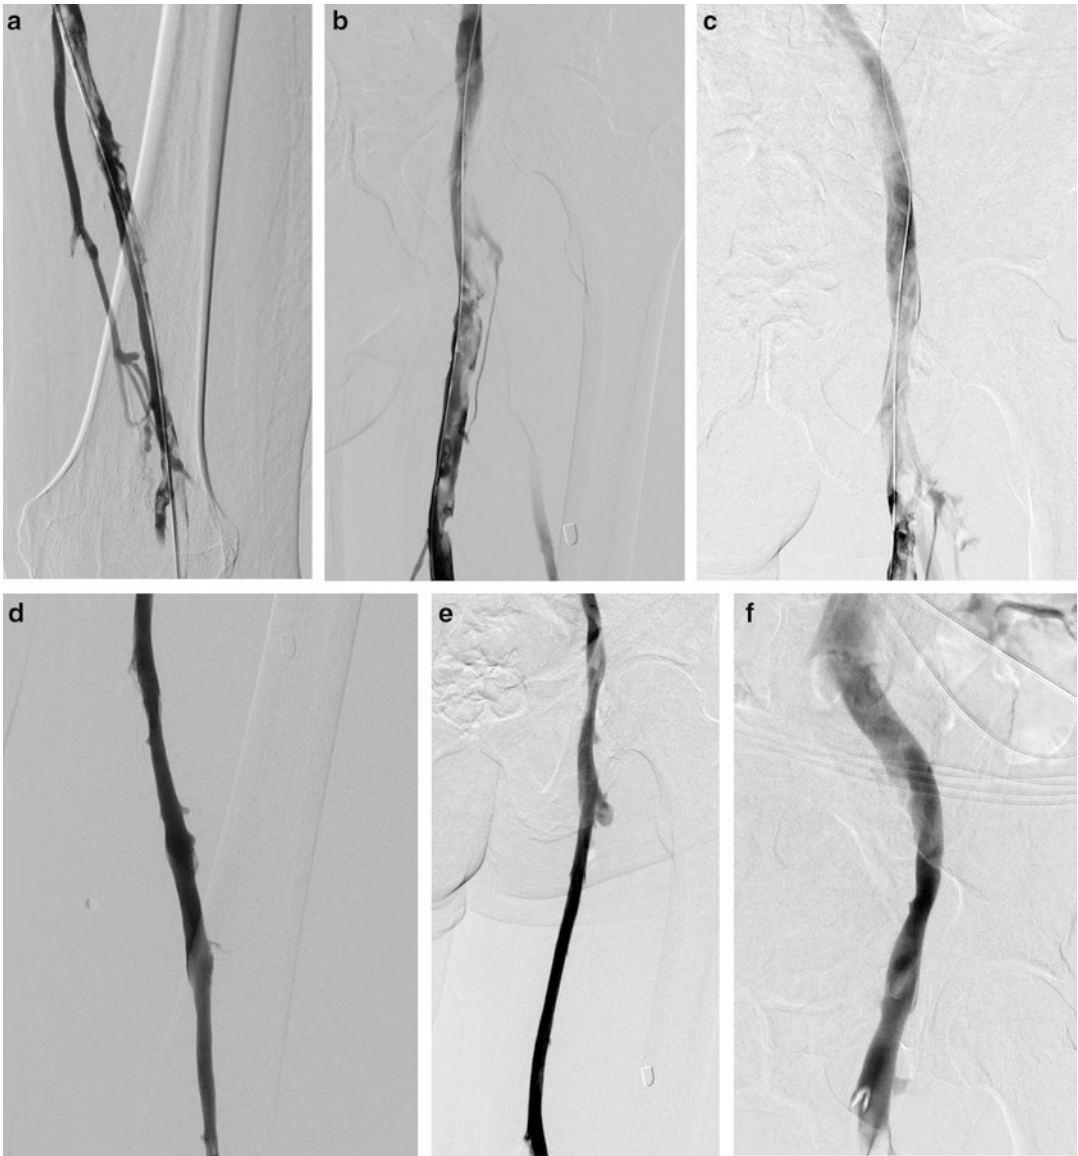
Sixty-three-year-old male with history of previous right lower extremity below the knee amputation with acute onset of left lower extremity pain and swelling. Duplex ultrasound (not shown) demonstrated acute thrombus in the left popliteal, left femoral, and left common femoral veins. Due to concern for thrombus extending into the iliofemoral system, a venogram was pursued. Vascular access was obtained in the left popliteal vein. Digital subtracted contrast venograms were obtained
